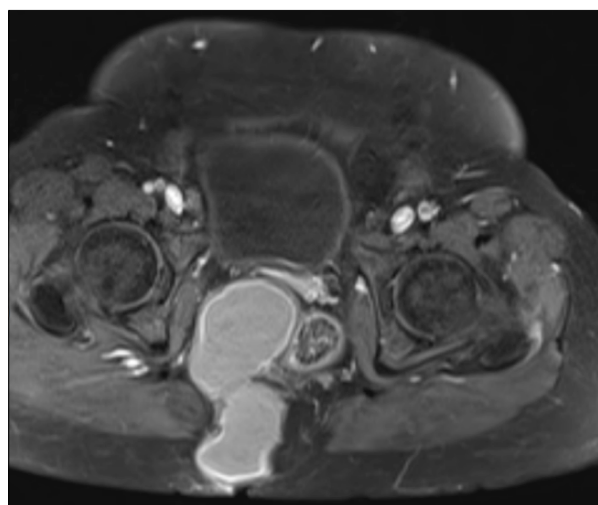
MRI excels in assessing soft tissue involvement and the extent of adjacent structure invasion.
